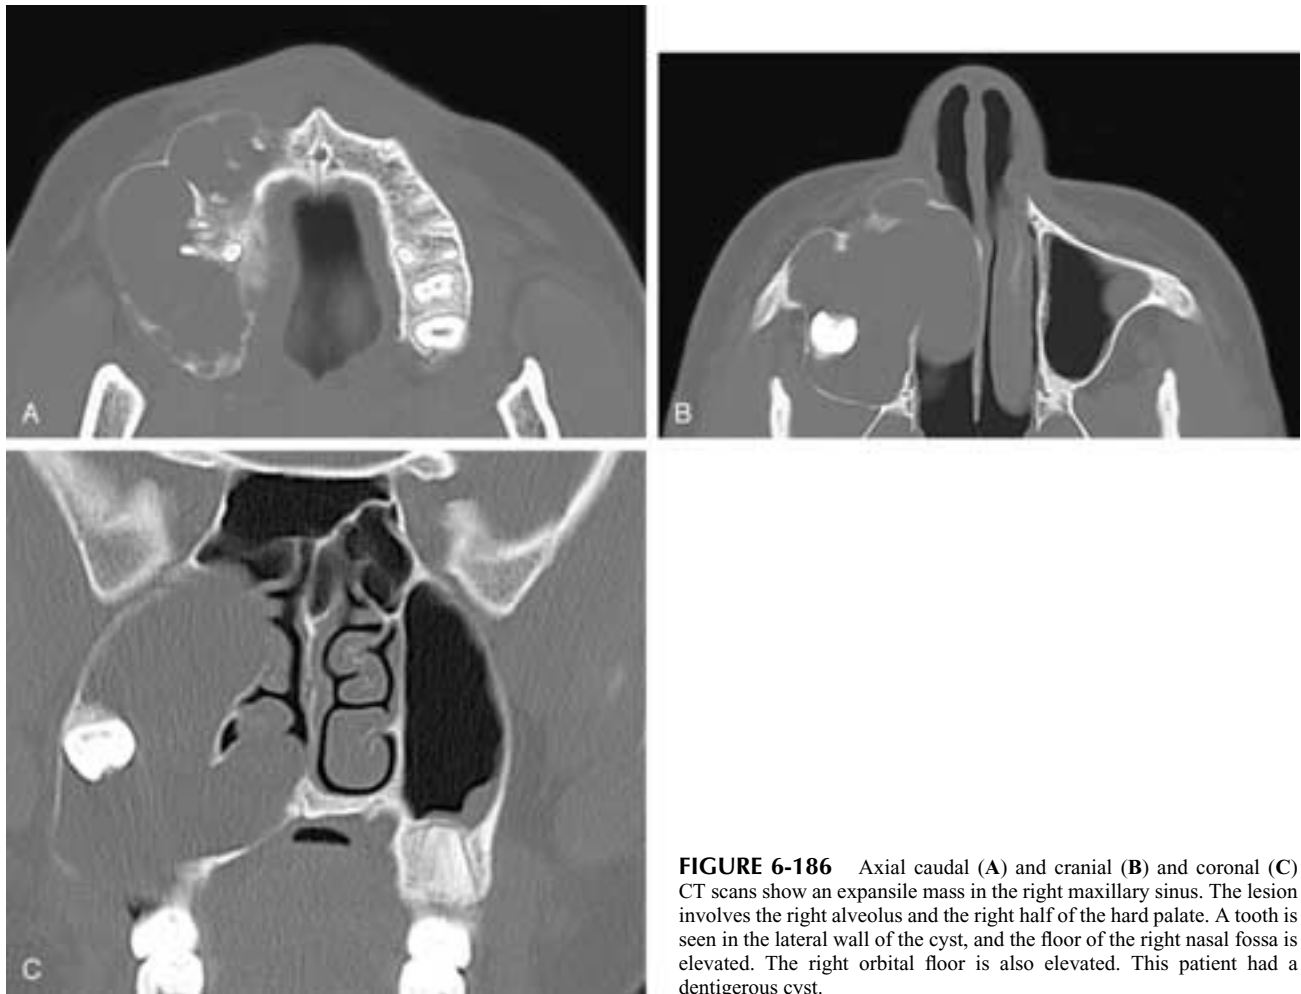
Axial caudal (A) and cranial (B) and coronal (C) CT scans show an expansile mass in the right maxillary sinus. The lesion involves the right alveolus and the right half of the hard palate. A tooth is seen in the lateral wall of the cyst, and the floor of the right nasal fossa is elevated. The right orbital floor is also elevated. This patient had a dentigerous cyst.
